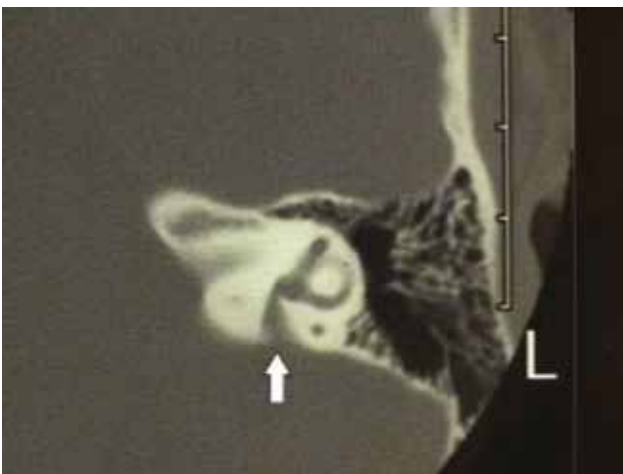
CT Temporal bone showing an enlarged vestibular aqueduct. This is not seen in patients with MD but the image demonstrates the position of the endolymphatic sac and duct and can be compared to the operative image in figure⁵.
